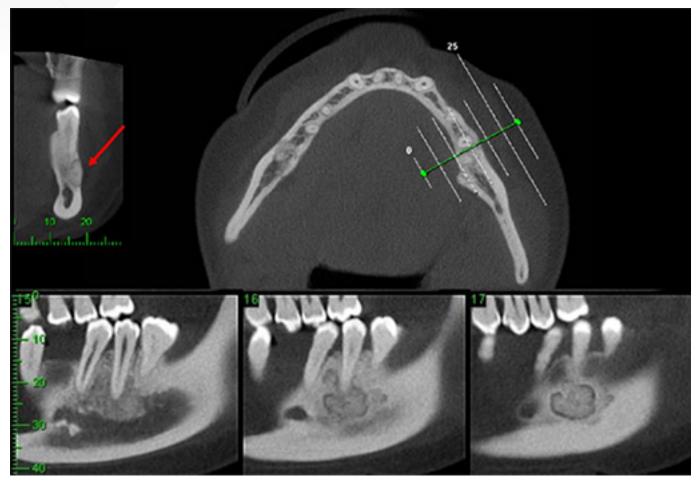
Heterogenous focal cemento-osseous dysplasia (ground-glass pattern) at the 35 periapical region. Extreme thinning of the adjacent buccal cortical plate is noted (red arrow).
